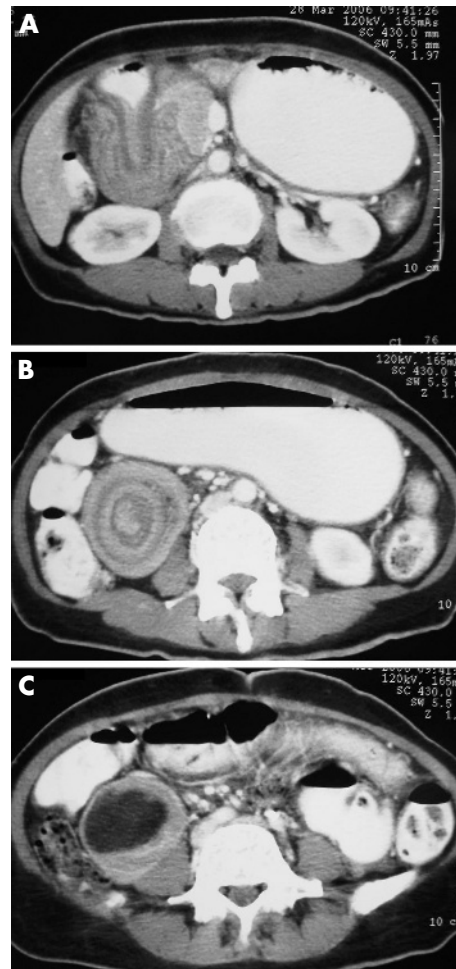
A–C; CT of the abdomen.
